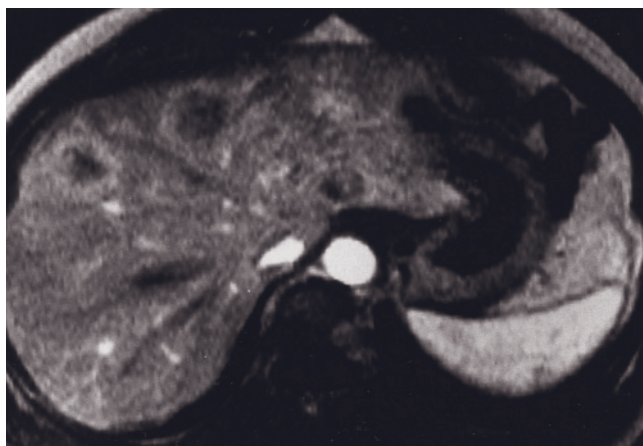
(Continued) and hypointense on T1-weighted images (f), and demonstrate ring enhancement on postgadolinium images (b). These liver metastases are poorly seen on T2 (e, g), well seen on T1 (f), and very well shown on immediate postgadolinium images (b).
